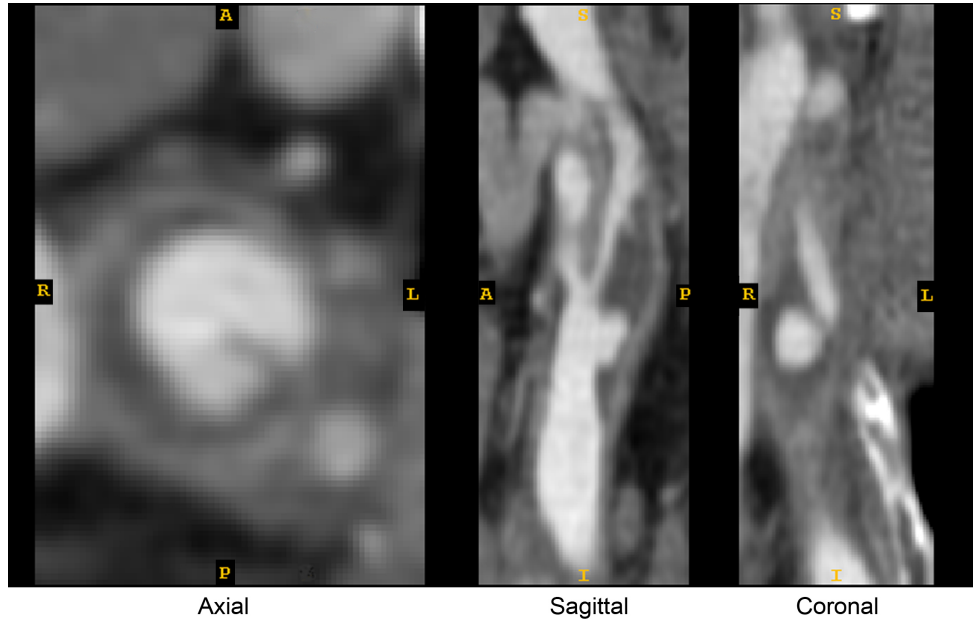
Axial, sagittal, and coronal views of diseased carotid bifurcation from CTA study.
